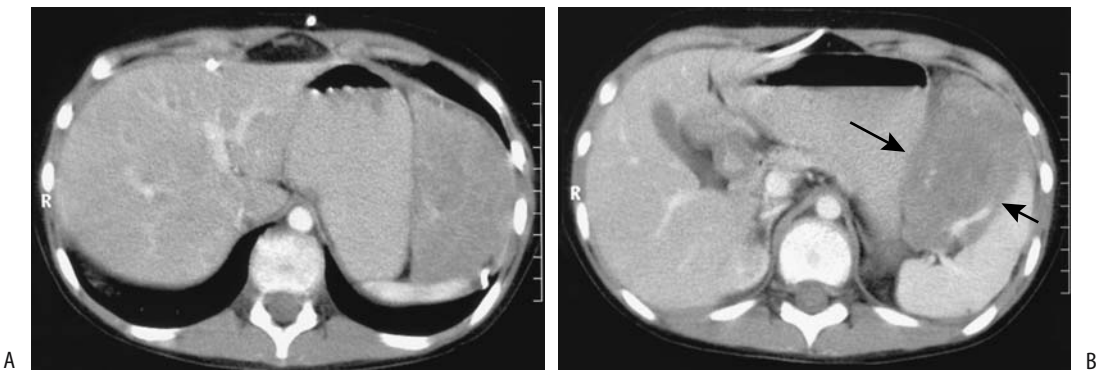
Metastatic germ cell tumor in a 12-year-old girl. A,B: Contrast-enhanced CT images reveal a large soft tissue tumor between the stomach and spleen (arrows). Patchy tumoral calcifications are present. (Courtesy of Algidas Basevicius, M.D., Kaunas Medical University, Kaunas, Lithuania.)
